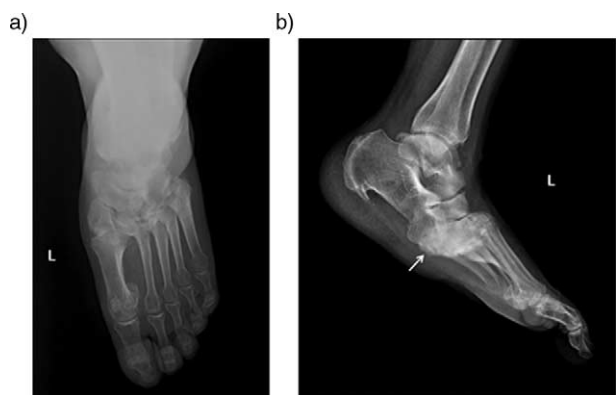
Anteroposterior (a) and lateral (b) plain radiographs of the left foot in a diabetic patient with chronic neuropathic arthropathy in the midfoot affecting the Lisfranc joint. Note plantar subluxation of the hindfoot (arrow) with typical ‘rocker-bottom’ deformity and dorsal subluxation of metatarsal bases.
